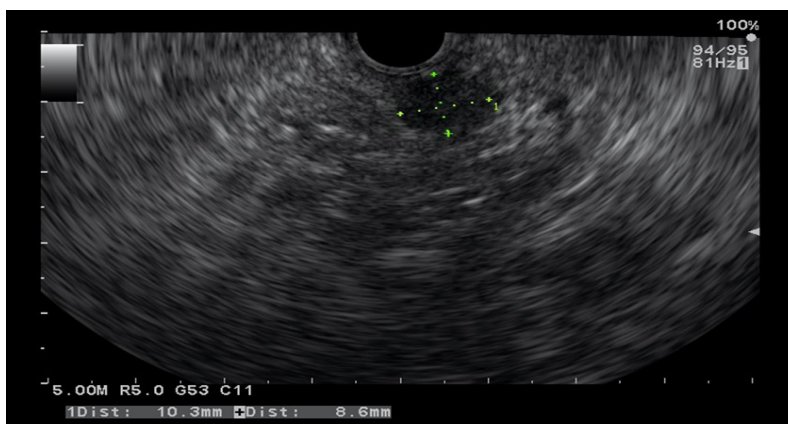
Hypoechoic circular pancreatic lesion at body of pancreas (10.3 x 8.6mm) on endoscopic ultrasound (EUS)
